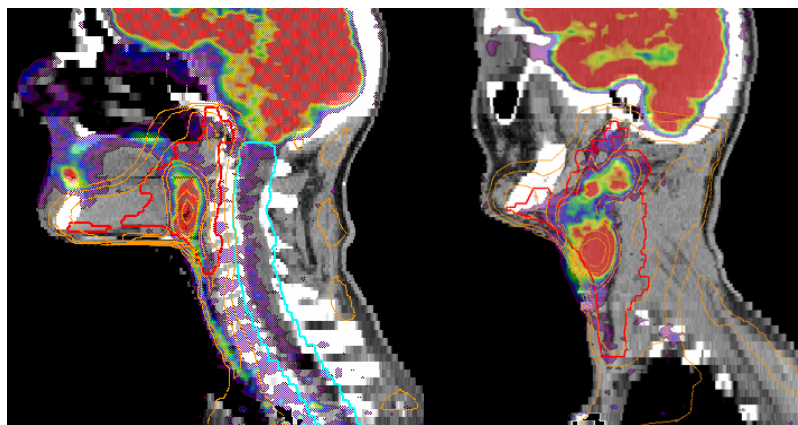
[^{18}F]FDG-PET-guided BCRT dose distribution superimposed on the original PET images for $D_{\text{high}} = 2.5$ Gy per fraction, shown for 2 sagittal planes (left: 0.3 cm to the left of the isocentre, right: 4 cm to the left of the isocentre). The 1.6, 1.8, 2.1, 2.2, 2.3, 2.4 and 2.5 Gy per fraction isodose lines are indicated in orange. The contours of the PTV (red) and the expanded spinal cord (cyan) are shown.
